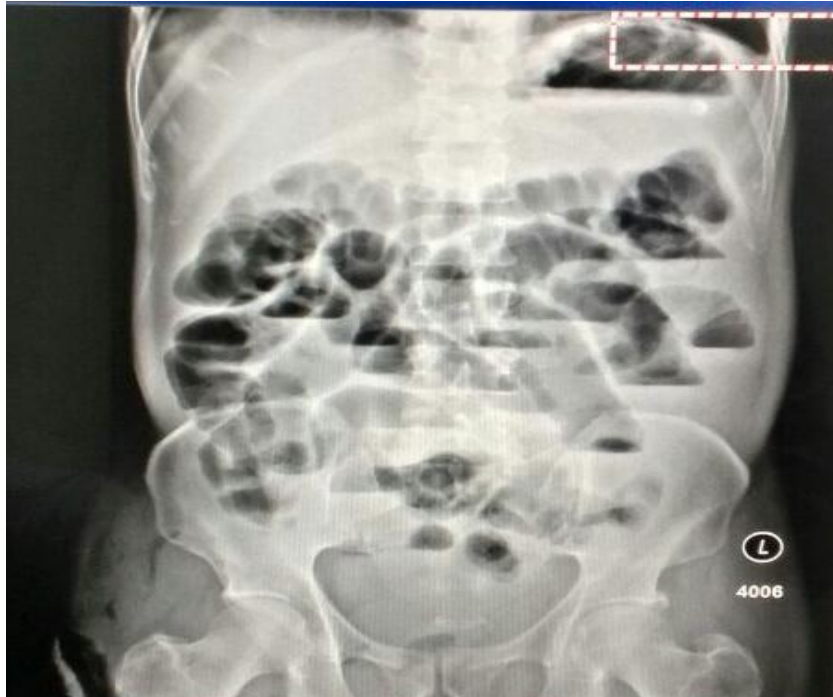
Abdominal X-ray with multiple fluid levels
